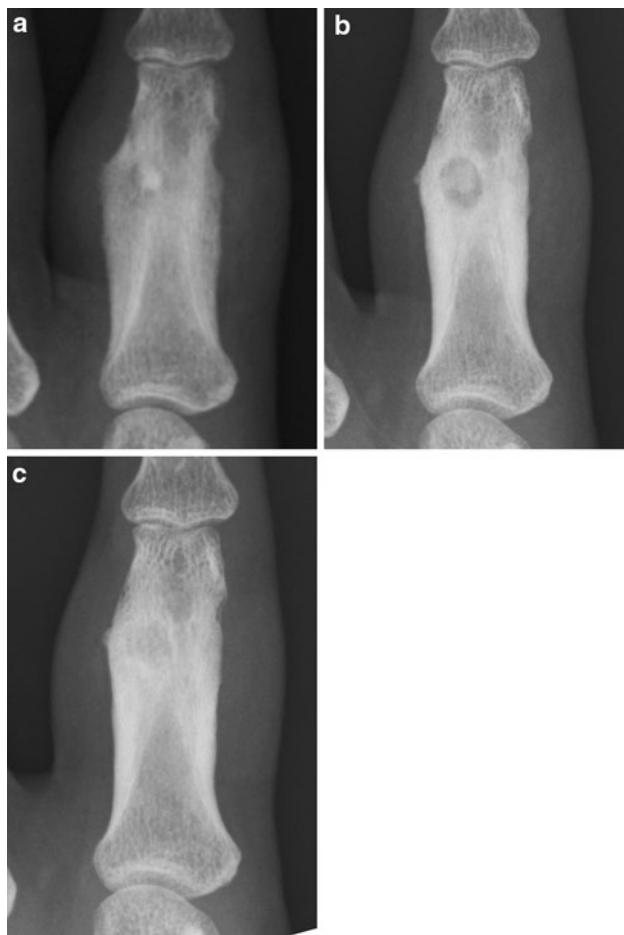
A 50-year-old woman with osteoid osteoma at the proximal phalanx of the left index finger (Patient 10). a, Plain radiograph at the first visit showed periosteal thickening of the cortex. A radiolucent area with calcification in its centre is seen in the thickened cortex of the ulnar side. b, Plain radiograph 2 years after the first visit showed clearer margin of the nidus than that seen in Fig. 2a. c, Plain radiographs 5 years after the first visit showed sclerotic change and diminution of the nidus, suggesting spontaneous regression
